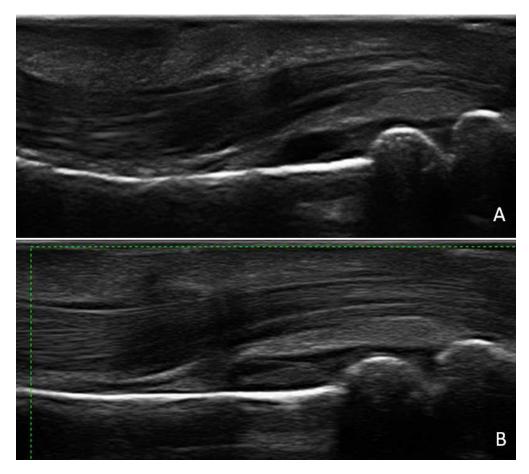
Longitudinal views of dactylitis belonging to the second group (dactylitis duration longer than 20 weeks). (A) Ultrasound shows no peritendinous oedema, distension of the flexor tendon sheath (grade 1) and of the capsule (grade 3) at proximal interphalangeal joint level. (B) PDS is absent in the articular, peritendinous and subcutaneous areas.
